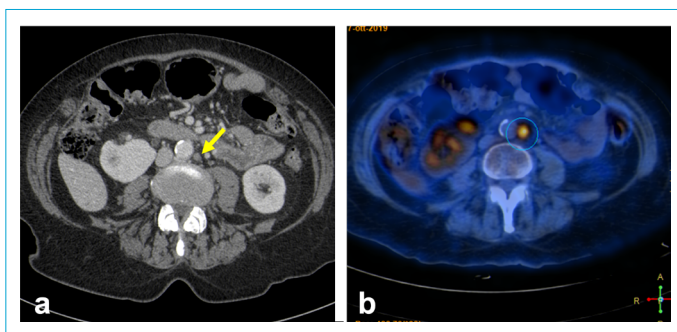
False-negative case. The patient was radically operated for G3 serous carcinoma of the ovaries, stage IIb, CA 125 at diagnosis 55 U/mL, adjuvant chemotherapy performed. At routine follow-up CT (a), performed in complete well-being, but with increasing CA 125 serum value (63 U/mL at the time of examination, 13 U/mL 3 months before), a 6-mm large, rounded para-aortic lymph node (arrow) was overlooked. On PET-CT (b) performed 3 months later because of further CA 125 increase (86 U/mL), the lymph node (circle) increased in size and showed increased glucose uptake, indicating tumor relapse.
